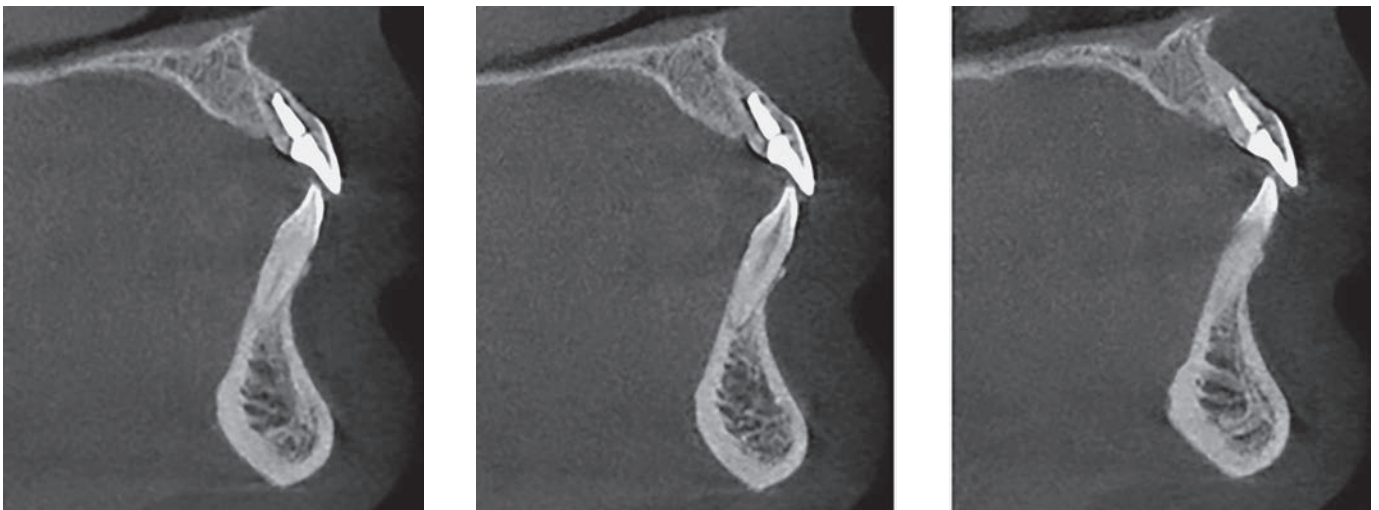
Cone Beam Sagittal sections, November 2016.
